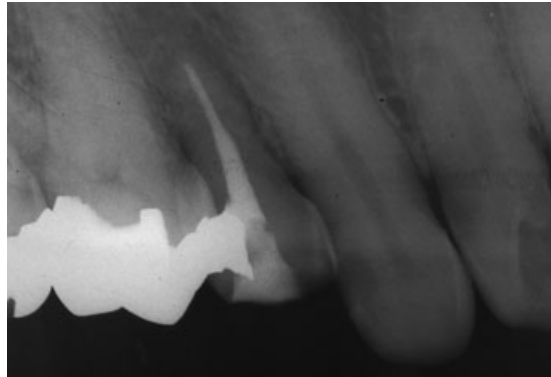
One-month follow-up radiograph after the root filling of root canal.
